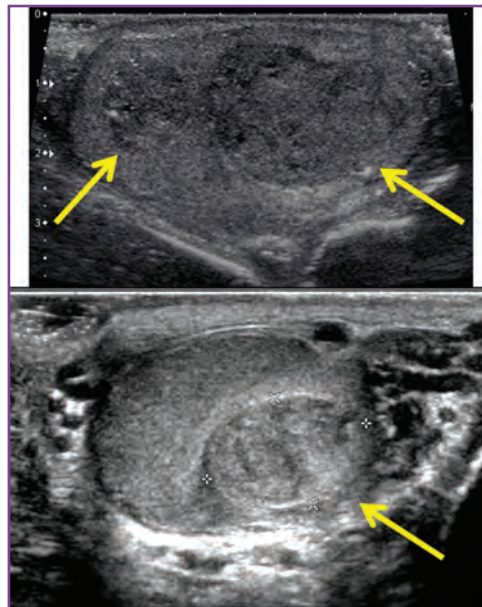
Scrotal ultrasonography shows testicular masses (arrows) in the same patient; be sure to look for multiple masses in the same testicle, as well as abnormalities in the opposite testicle.
